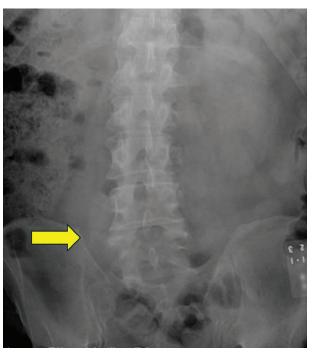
Postoperative lumbar spine radiograph after successful pseudoarthrectomy (yellow arrow).
